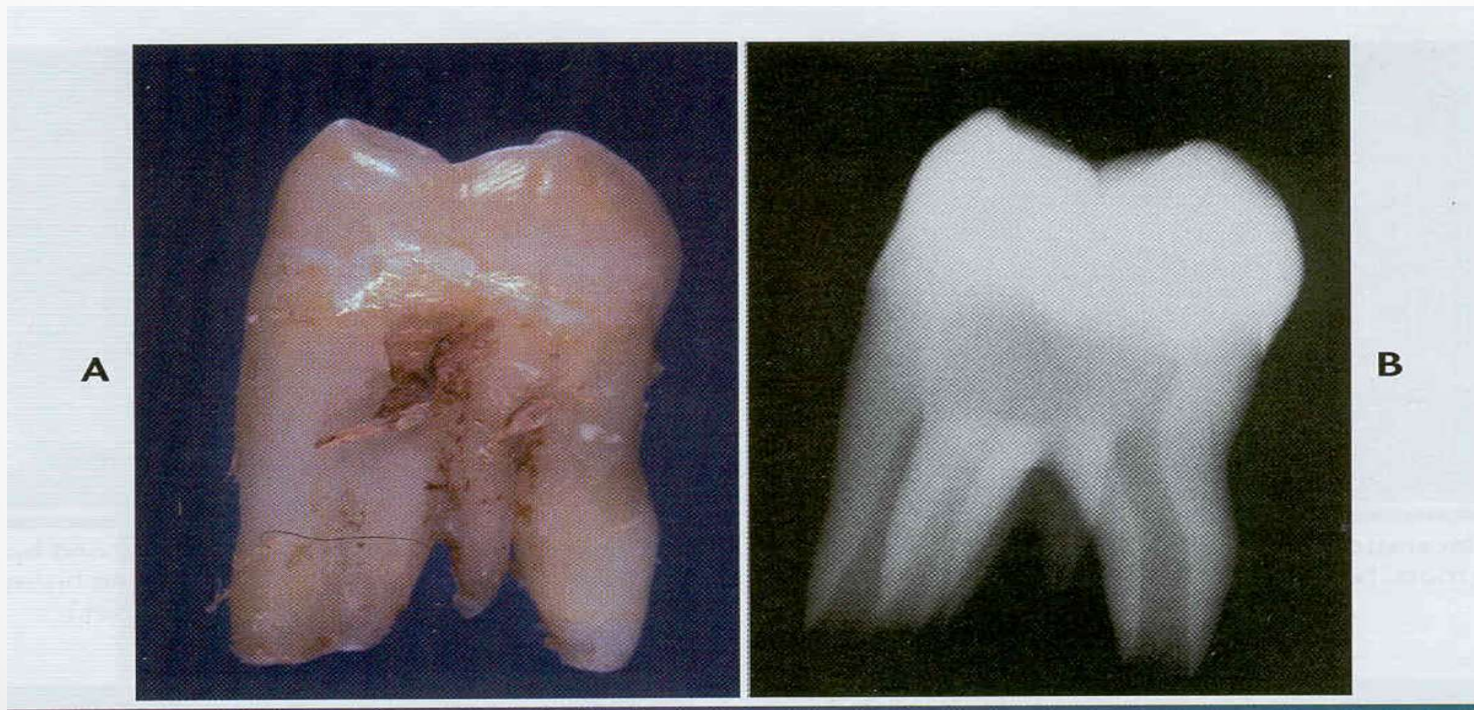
♦ Supernumerary root. A, Gross photograph exhibiting a maxillary molar with a small supernumerary root. B, Mesial-to-distal radiographic view exhibiting the accessory root with central pulp canal. If a buccal-to-lingual radiographic view had been taken (as would be necessary in patient care), the additional root would not have been evident.
